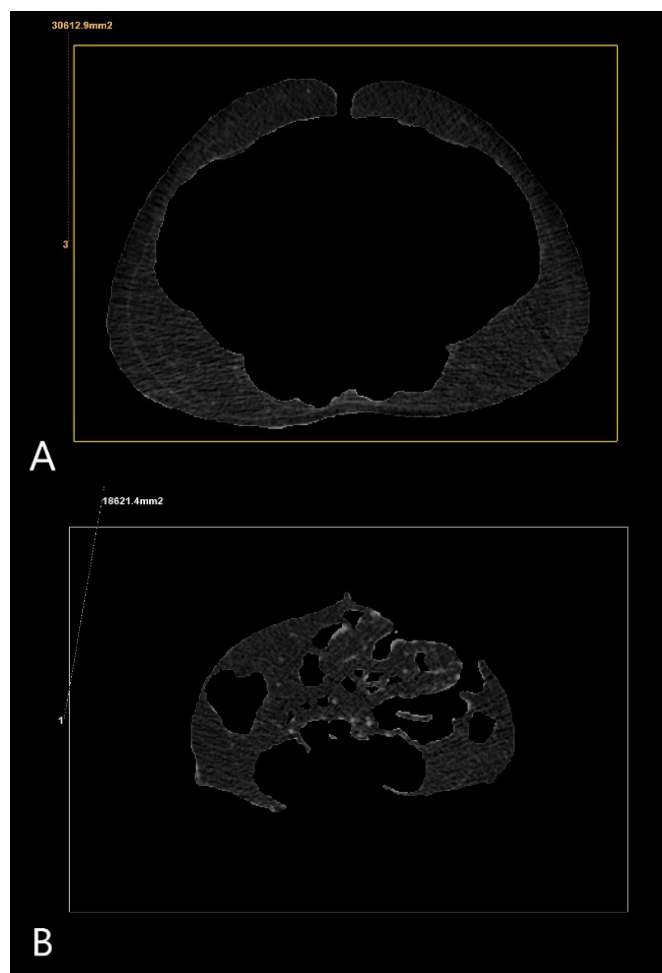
Measurement of SFA and VFA at the level of the umbilicus on a non-contrast abdominal CT scan of a 49-year-old male patient. A) shows the SFA measurement, recorded as 306.12 cm^2 . B) shows the VFA measurement, recorded as 186.21 cm^2
